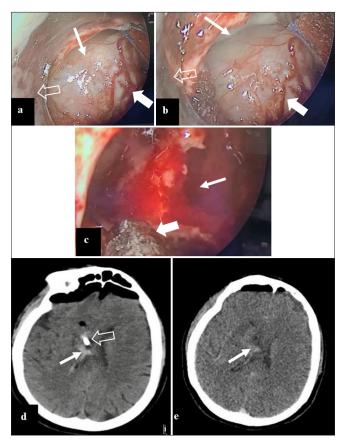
(a) Intraoperative image, showing a brownish gray tumor (thin arrow), hypervascularized (thick arrow), by endoscopic view using a handmade endoport (empty arrow). (b) Intraoperative endoscopic image with a handmade endoport (empty arrow), where the same tumor is shown (thick arrow) with defined borders (thin arrow) that allow distinguishing the tumor from the medial wall of the right frontal horn of the lateral ventricle. (c) Intraoperative image with partial resection tumor with moderate bleeding (thin arrow), where the resection continued with aspiration (thick arrow). (d) Nonenhanced brain computed tomography (CT) on the 1st postoperative day, absence of tumor, with little bleeding in the surgical field is shown (thin arrow), also the distal end of the external ventricular catheter is seen (empty arrow). (e) Enhanced brain CT on the 5th postoperative day, without external ventricular shunt, where there is no evidence of contrast-enhancing lesions, with little bleeding in the surgical field (arrow).
